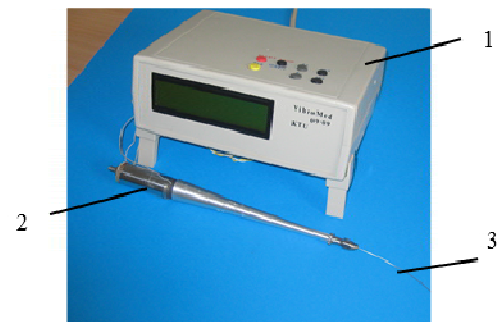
The ultrasonic blood- vessel recanalization system
